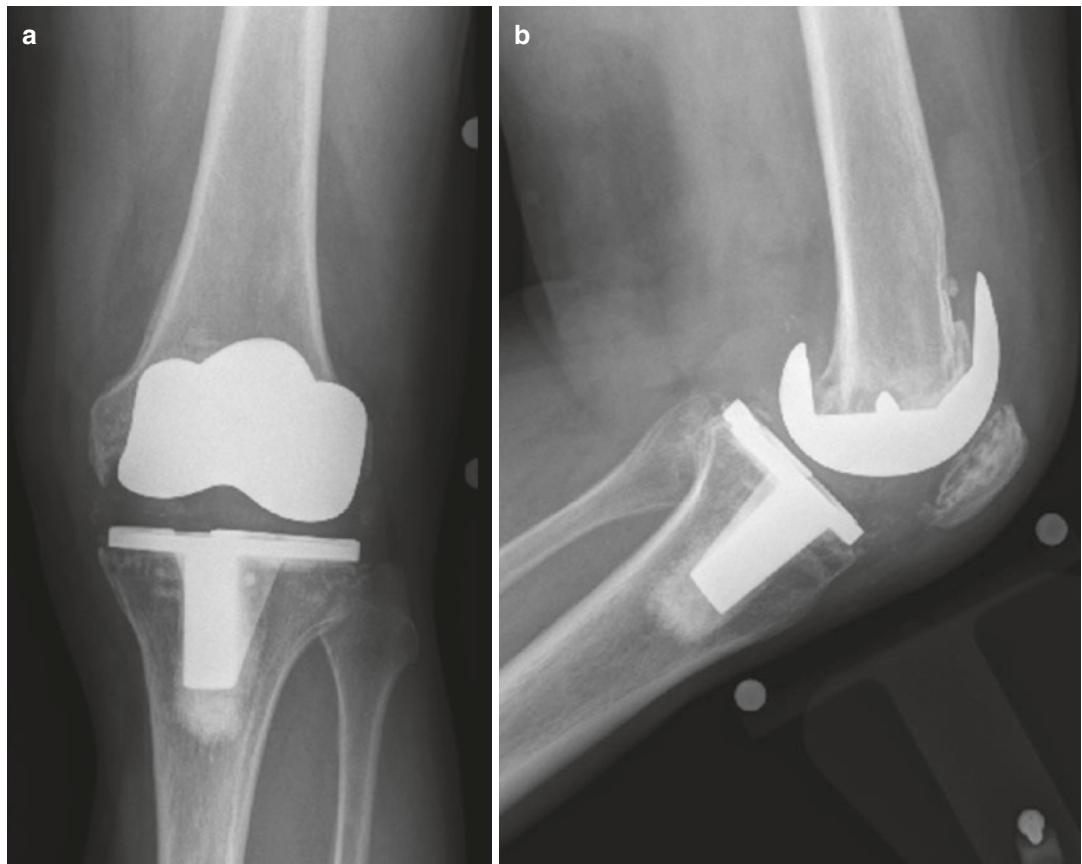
Presenting anteroposterior and lateral radiographs of 64-year-old male with knee pain and instability symptoms. The tibial component appears secure, but there
